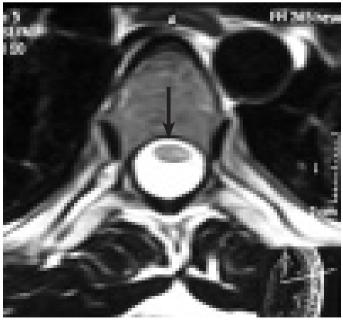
Axial T2-weighted image shows hyperintense lesion at the level of T-4.
